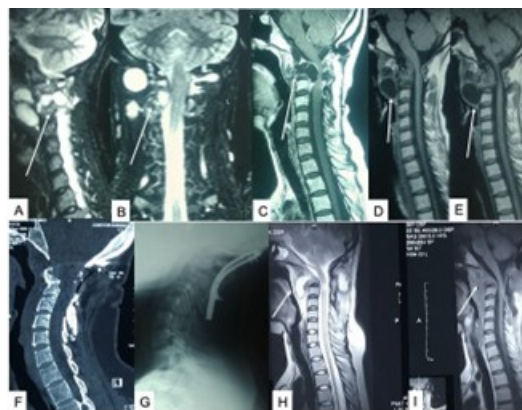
(A–I) MRI of CVJ showing hydatidosis (Echinococcosis) with instability and cord compression. Source: Figure by authors.
